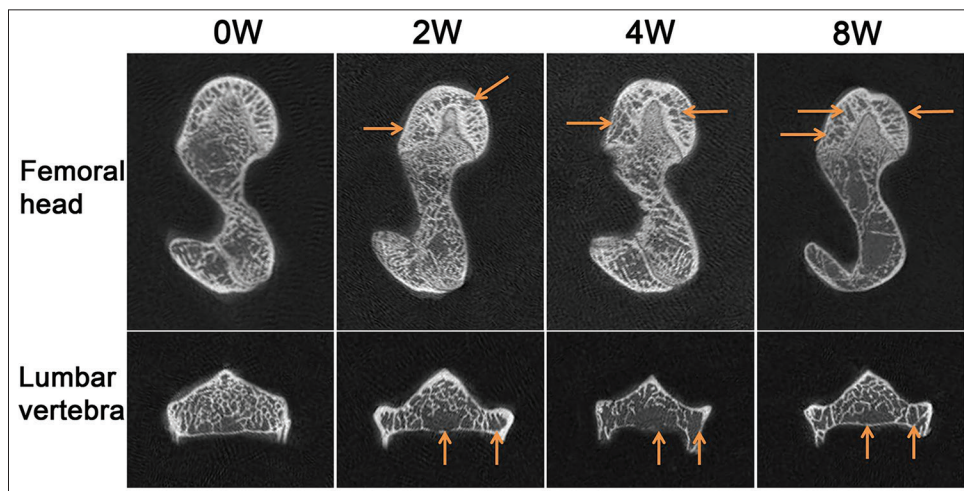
Micro-computed tomography image of the femoral head and lumbar region showing the peculiarity of uniformity and solid reticulation at 0 weeks. There were subchondral cystic changes in the femoral head after 2 weeks, the number and size of these lesions increased at 4 and 8 weeks. The trabecular bone structure in the lumbar vertebrae L4 was uniformity and solid reticulation at 0 week, then disorderly and uneven after 2 weeks, and the trabecular bone collapsed into fractures after 4, 8 weeks
